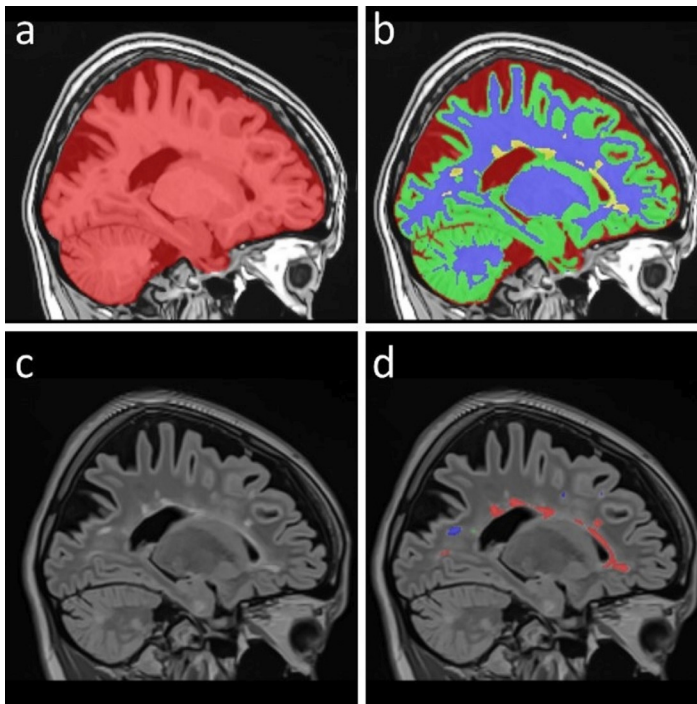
Analysis of 3D MR images with VolBrain software. Intracranial cavity extraction from 3D T1W images (a), gray/white matter discrimination (b), 3D FLAIR image (c), and detection of MS plaques (d).
